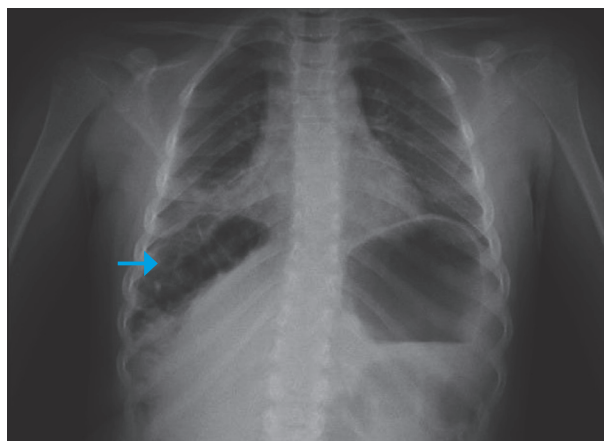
Chest radiograph. Chilaiditi sign: right hepato-diaphragmatic interposition of the colonic haustration. Middle lobe consolidation. Absent visualization of right diaphragm suggesting pleural effusion.
